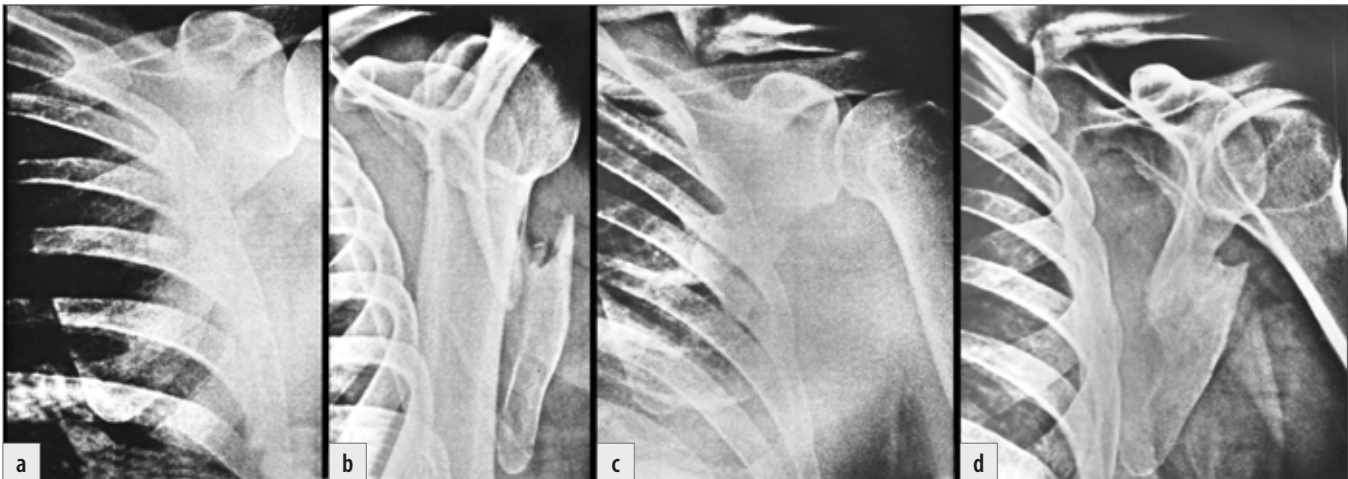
Nonoperative treatment of an infraspinous fracture of the scapular body in a 55-year-old man: a+b) post-injury radiographs in the anteroposterior and Y-views showing an evident shortening of the lateral pillar; c+d) Near l and ap projections of the shoulder joint 6 months post injury show healing in the original position.
